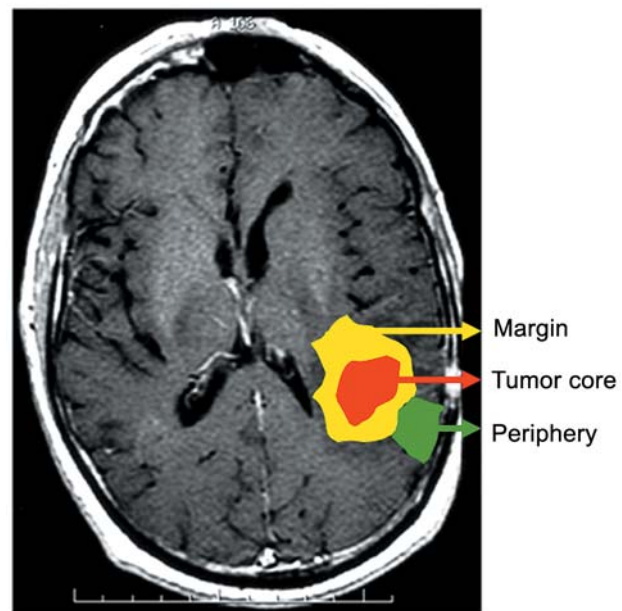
MRI of representative tumor, indicating sampling areas (periphery, margin and core).
